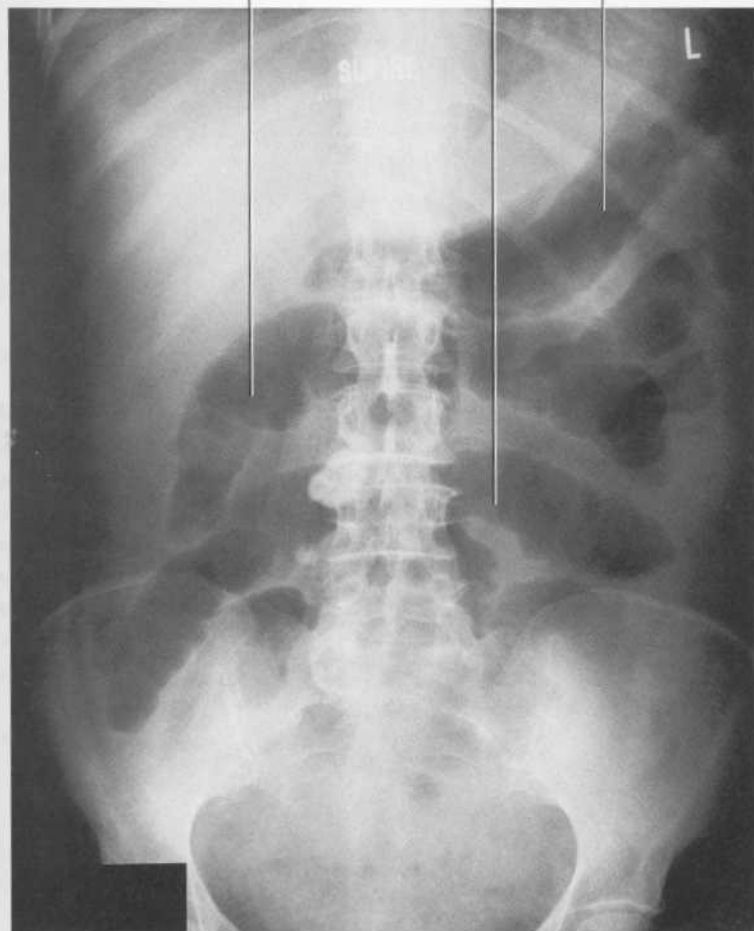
This is the supine abdominal radiograph of a patient presenting with abdominal pain, distension, nausea and vomiting. Note absence of fluid levels.
